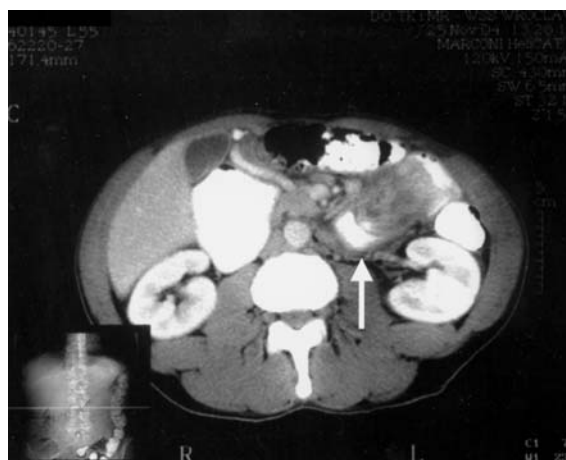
CT with contrast medium – heterogenic structure that crowds into the contrasted intestinal loop
